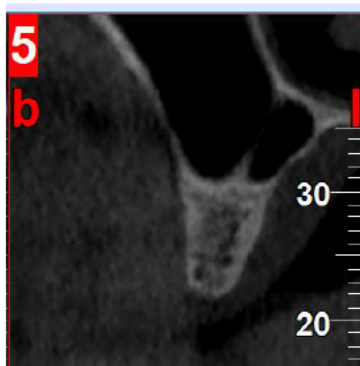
CBCT detection of a vertical sinus septum in the cross-sectional image.
